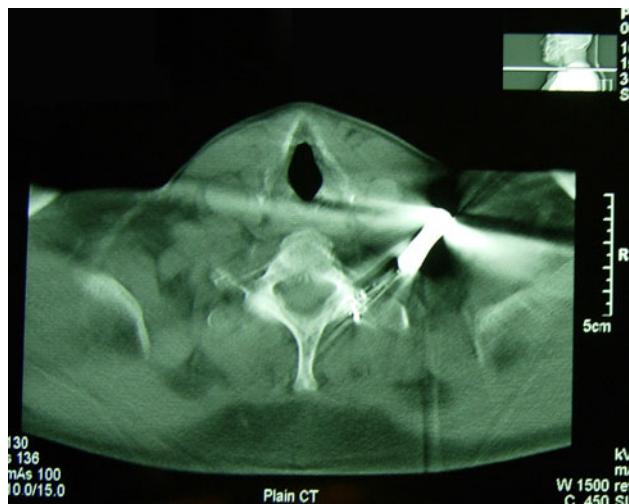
Axial section of CT image showing bullet
